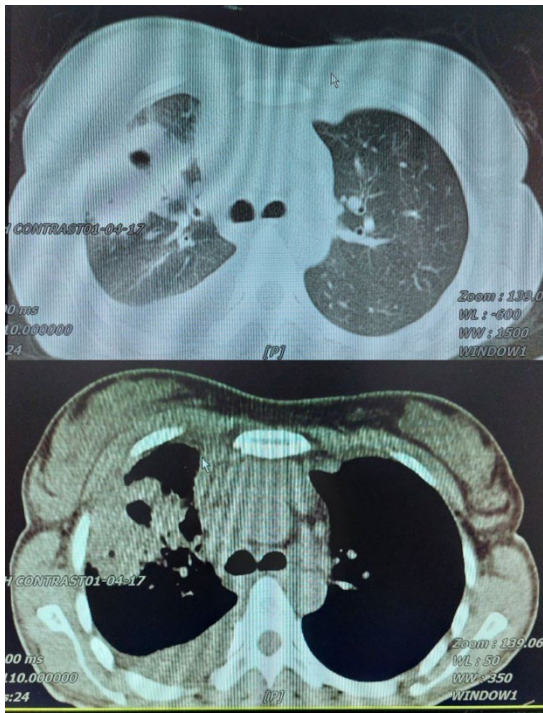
Lung computed tomography imaging. Both images show a right pulmonary consolidation along with pleural effusion (upper image taken at lung density)
